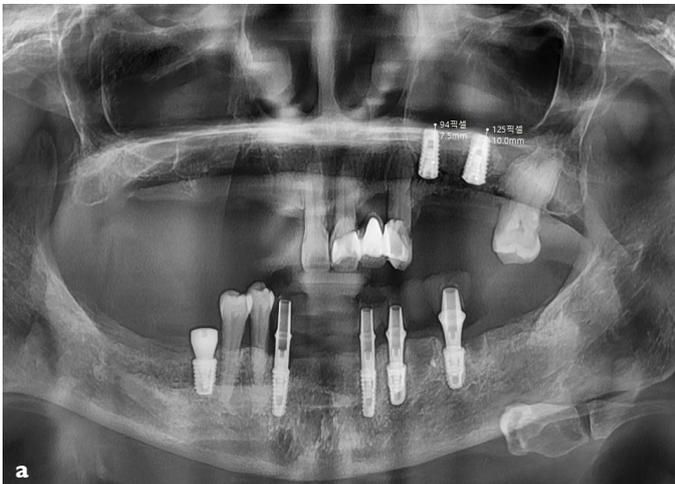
(a-b). Post-operative x-ray f/u
